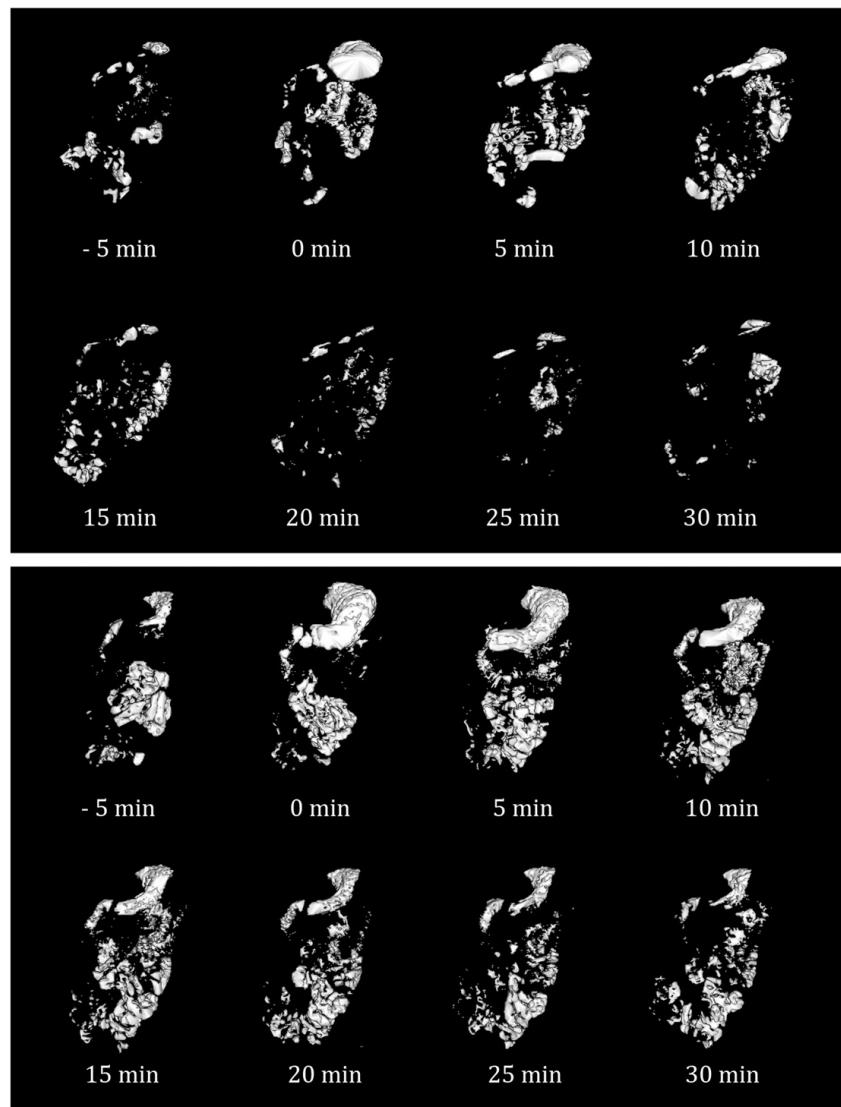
Two examples of gastrointestinal water distribution directly before (-5 min) and after ingestion of 240 mL under fasting conditions. In these T2-weighted MR images only water is shown.
